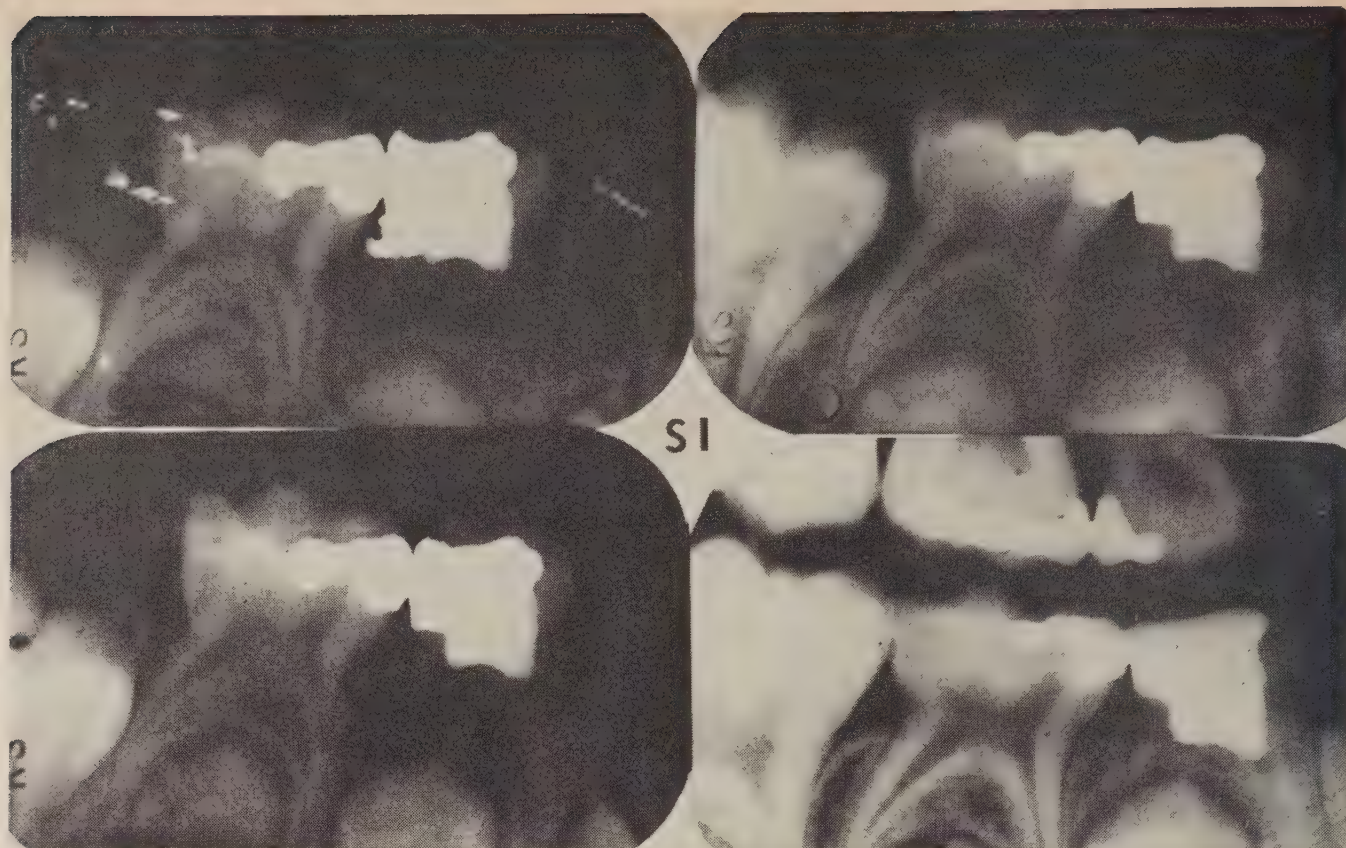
Progressive radiographs of a left mandibular first primary molar with pulp exposure. A large fistula originated from this tooth. The patient also had a mild cellulitis. The fistulous tract was scraped and a pulpotomy was performed, using N₂ Medical and a temporary cement. One day later the cellulitis had subsided. The dressing was replaced one week later by N₂ Permanent and an amalgam restoration. The fistula was healing at that time. The postoperative radiograph (top left) shows extensive bone destruction around the distal root. A radiograph taken nine months later (lower right) shows complete reversal.
